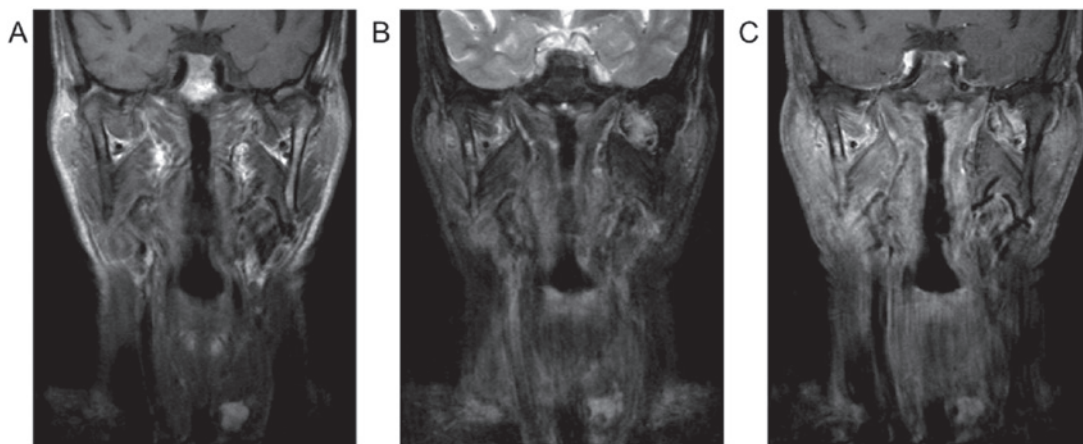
MR images of thyroid lesion. (A) T1WI image shows high signal intensity, (B) STIR image demonstrated high signal intensity, and (C) CE-T1WI shows strong enhancement.
